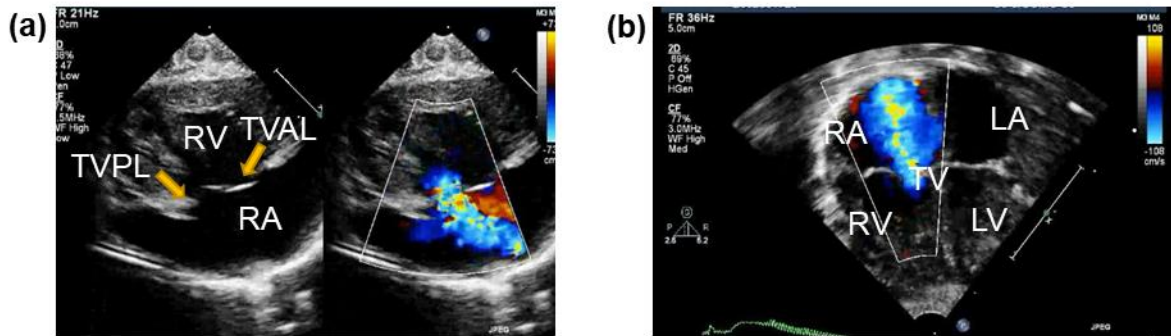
Visualization of severe tricuspid regurgitation using two different 2D transthoracic echocardiography views and color flow Doppler: (a) a parasternal long-axis inflow view, and (b) an apical four-chamber view of a newborn with a severe pulmonary hypertension due to diaphragmatic hernia. (Images provided by Drs. Mir and Burkhart at the OUHSC)
